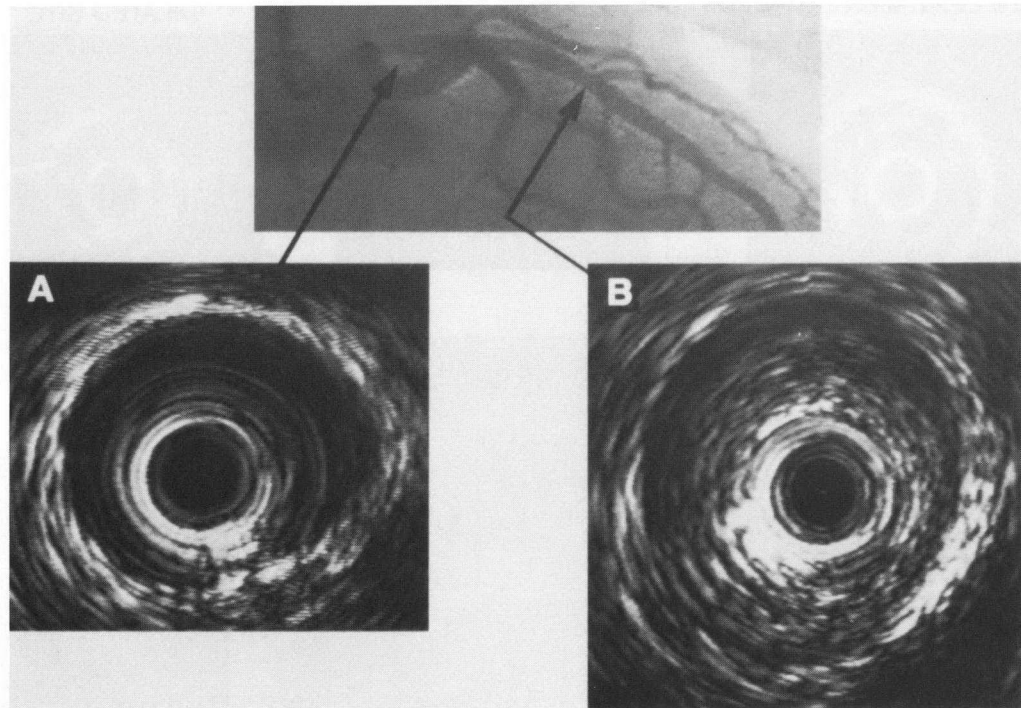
Napkin ring stenosis: Improved diagnosis by intravascular ultrasonography. This healthy 47-year-old woman had an abnormal treadmill stress test and typical symptoms of angina. The findings at angiography were unimpressive but suggested a mild narrowing in the ostial left anterior descending (LAD). Because there was clinical suspicion of severe disease, intravascular ultrasound imaging was performed. This revealed information that was contrary to the angiographic appearance. (A) In the proximal ostium of the LAD where there appeared to be tapering in the angiographic image, but there was no evidence of atherosclerotic disease was seen with IVUS. Beyond this area, there was a small amount of atheroma and compensatory dilatation. (B) An area that showed a less than 50% stenosis by angiography, but where intravascular imaging shows a nearly occlusive, short, napkin ring stenosis.
